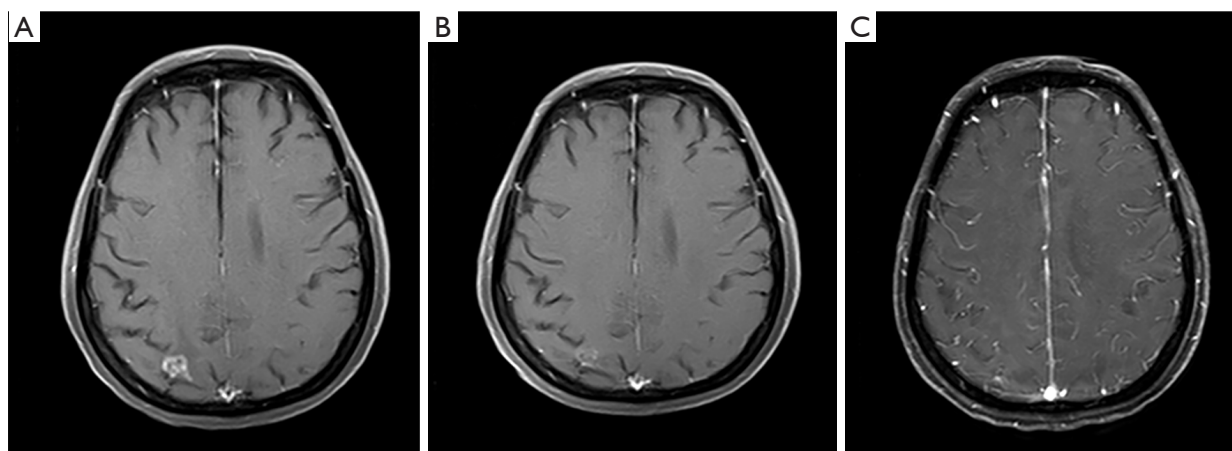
The brain MRI of the patient during the course of disease. (A) The lesion in the right parietal lobe enlarged after erlotinib and whole brain radiotherapy. (B) The BM in the right parietal lobe nearly disappeared after osimertinib treatment. (C) The BM in the right pons and the original lesion in left cerebellar hemisphere nearly disappeared after osimertinib treatment. MRI, magnetic resonance imaging; BM, brain metastasis.
